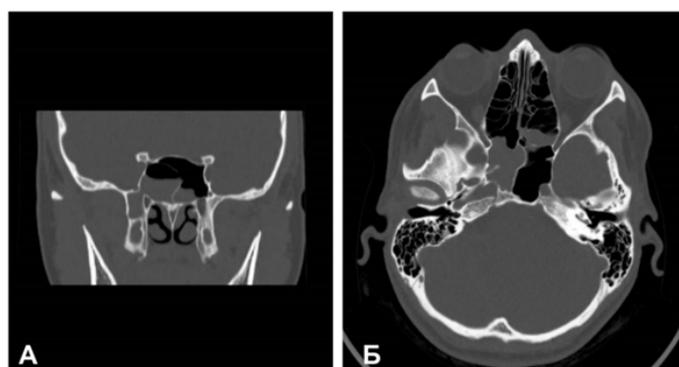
Computed tomography of the paranasal sinuses of patient P. before surgical treatment. A - coronal projection, B - axial projection.
